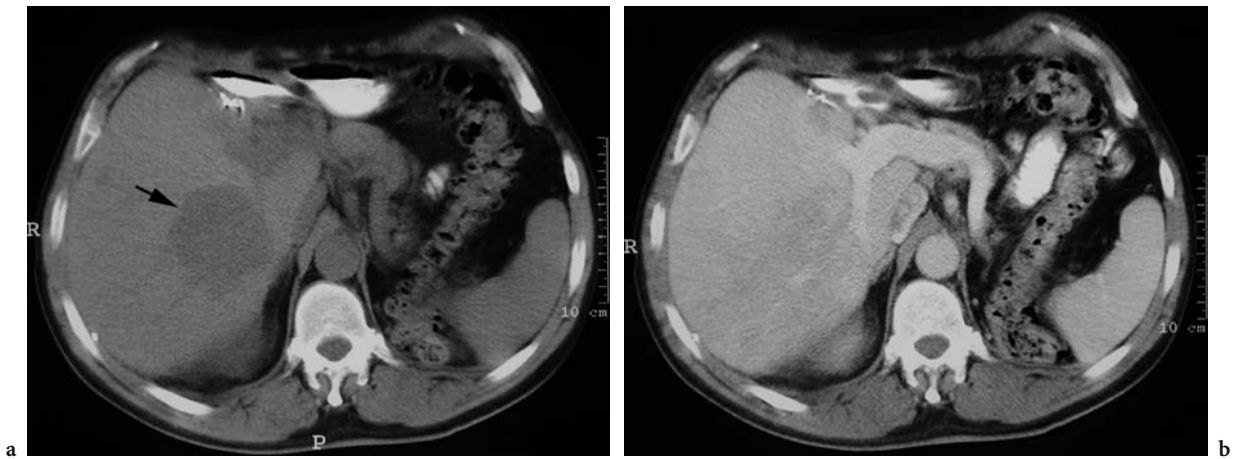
Liver metastasis in a 51-year-old man who underwent left nephrectomy for renal cell carcinoma. a Axial unenhanced conventional CT scan shows a large, round hypodense mass lesion in the liver (*arrow*) which is barely detectable (b) after contrast injection.
